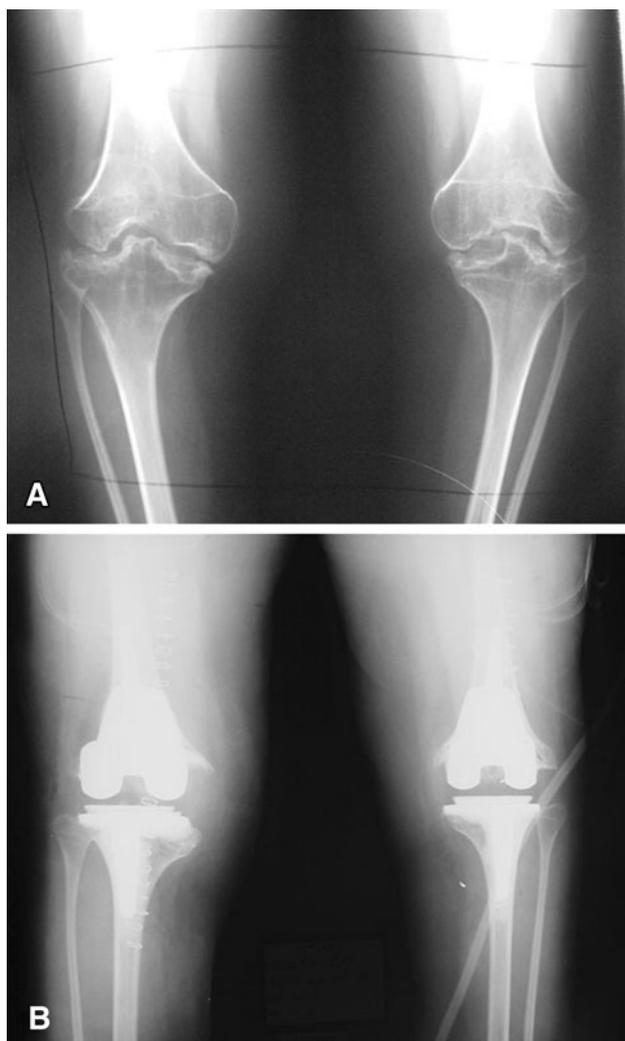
The AP radiographs of this patient with juvenile idiopathic arthritis show bilateral marked joint destruction (A). Custom total knees were used as a result of patient size and offset of the tibial stem (B).
